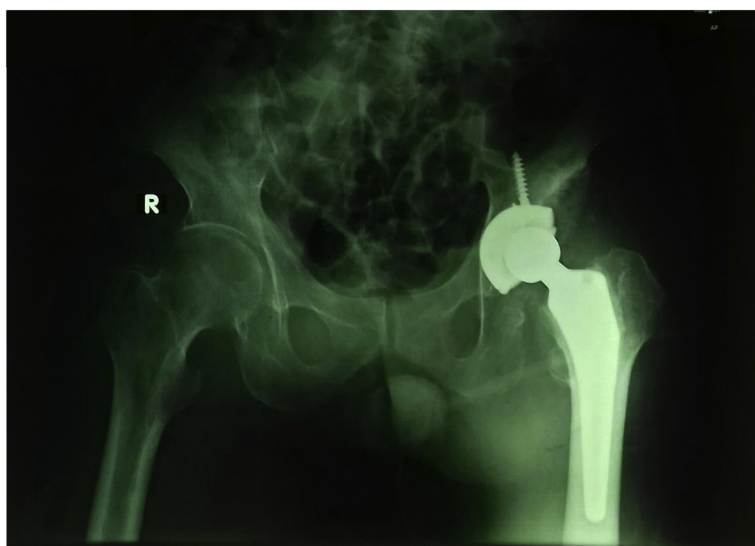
Radiographic image after total hip arthroscopy surgery.
